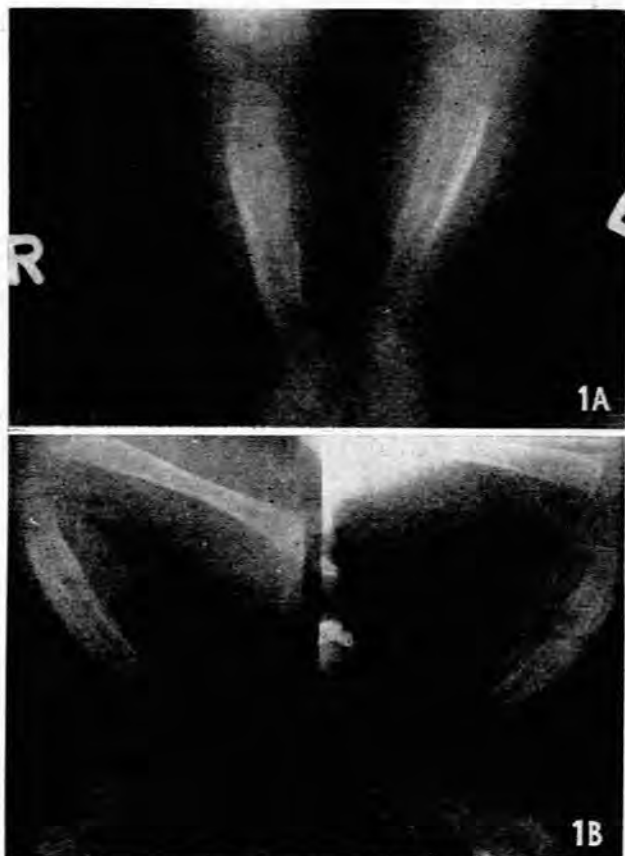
A and B. Antero-posterior and lateral radiographs of legs, demonstrating the extensive periosteal new-bone formation of both tibial shafts and right fibula with a tendency to onion-peel layering.
